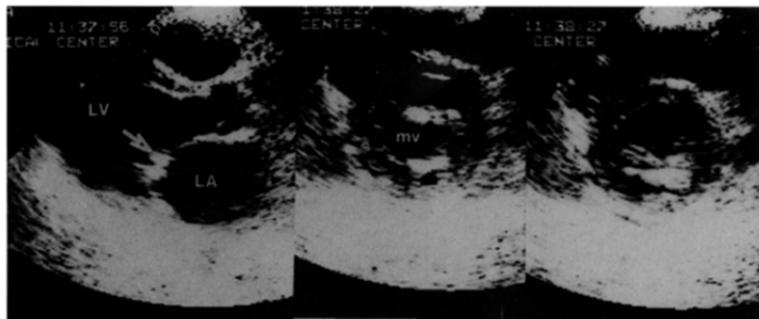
Patient 2. Apical four-chamber view in a 39-year old man. Thickening of the subvalvular mitral apparatus with fusion of chordae tendineae is noted (white arrow). RV = right ventricle; other abbreviations as in Figure 1.
